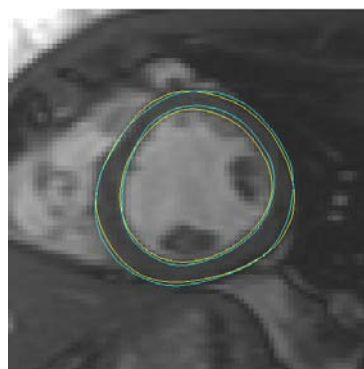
expert (yellow) and propagated (cyan) contours for a mid-diastole cardiac MRI image
